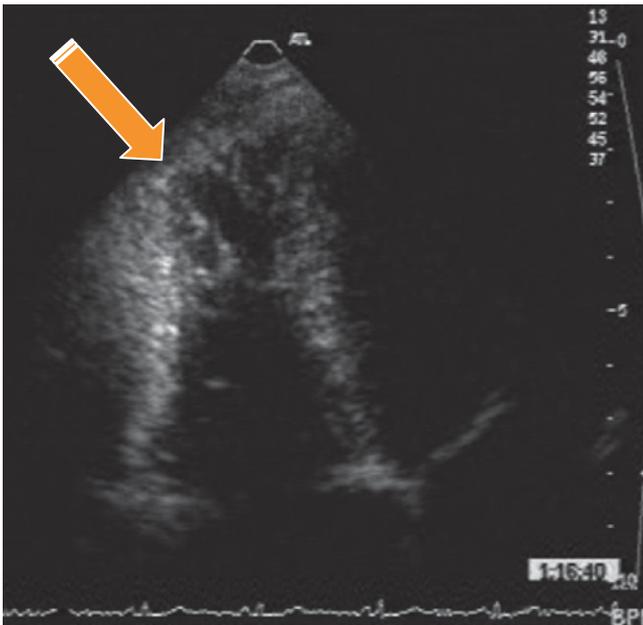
Same patient as in Fig. 25.3. Apical four-chamber demonstrating the discrete aneurysm at the apex (*arrow*)
